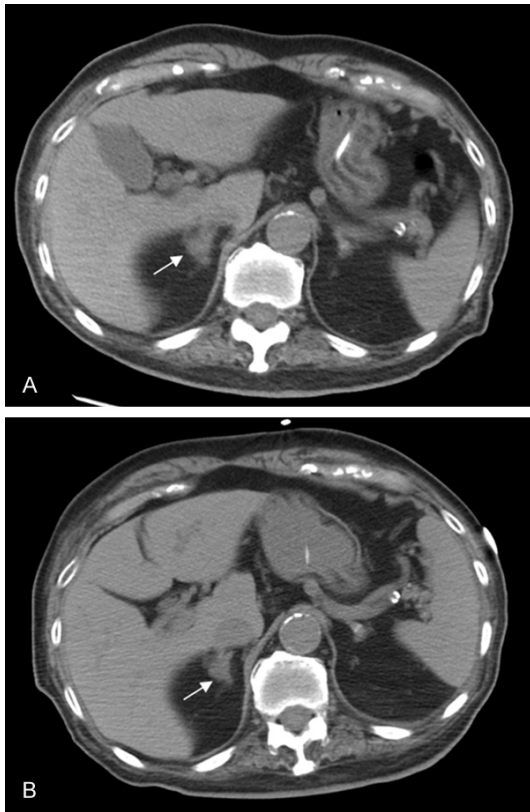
Abdominal computed tomography scan showed nodular mass on the right adrenal gland. A: CT was performed in 26th September 2013 and nodular mass was 16 mm in diameter (arrow). B: CT was performed in 20th October 2014 and nodular mass was 14 mm in diameter (arrow).
